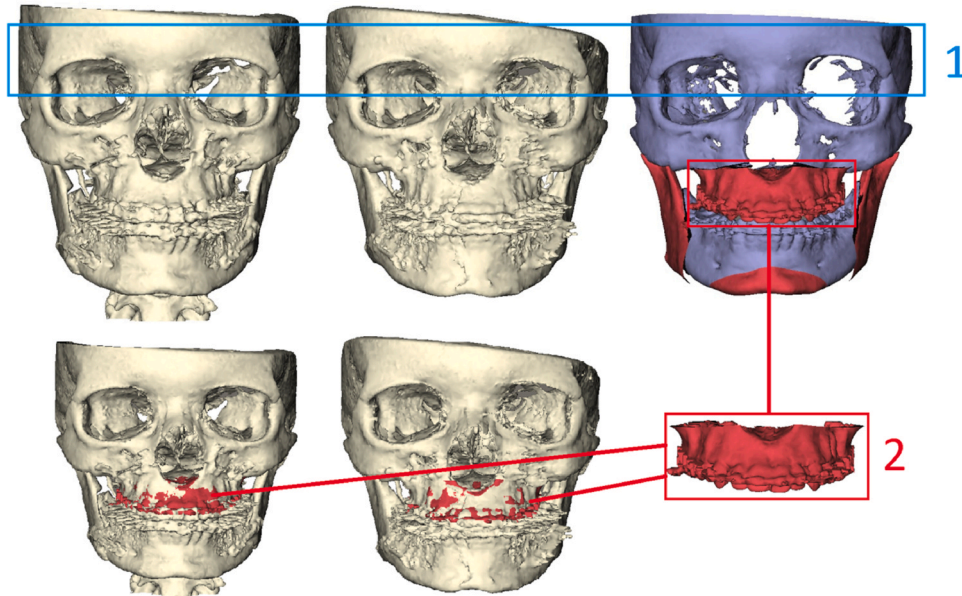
Quantification of maxilla movement: (1) alignment of the 2-week and 1-year postoperative CBCT scans with the planning, based on the anterior skull region of interest; (2) alignment of the osteotomized maxilla with the 2-week and 1-year postoperative CBCT.
